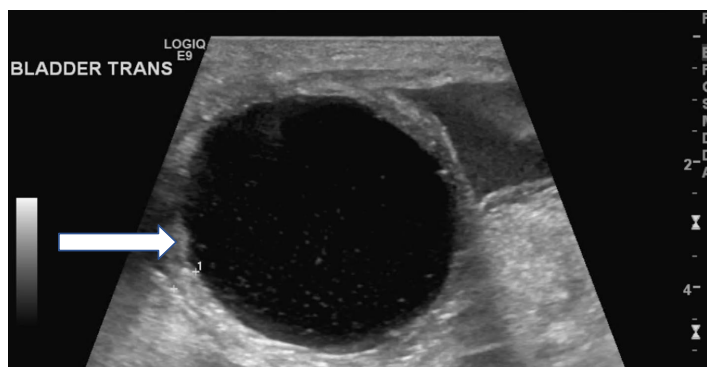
Ultrasound of Bladder that reveals a markedly distended bladder with mildly thickened wall (white arrow).
